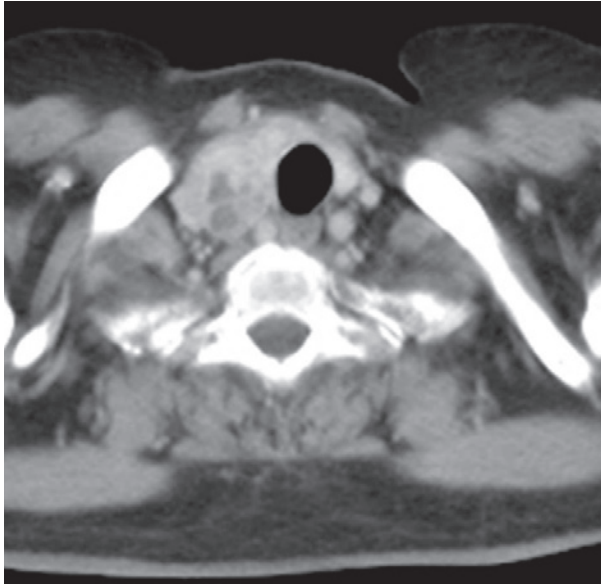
Neck enhanced CT. A mass 3.5cm in size is visible in the right lobe of thyroid gland. It excludes the thyroid capsule, although the boundaries are clear. The mass inside shows conspicuous cystic degeneration is with a slight tracheal midline displacement.
